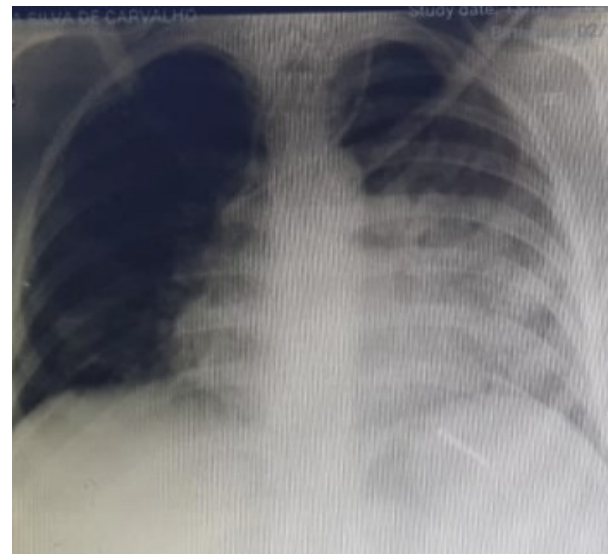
Antero-posterior chest x-ray 24 hours after the prone position showing improved dense infiltrates
